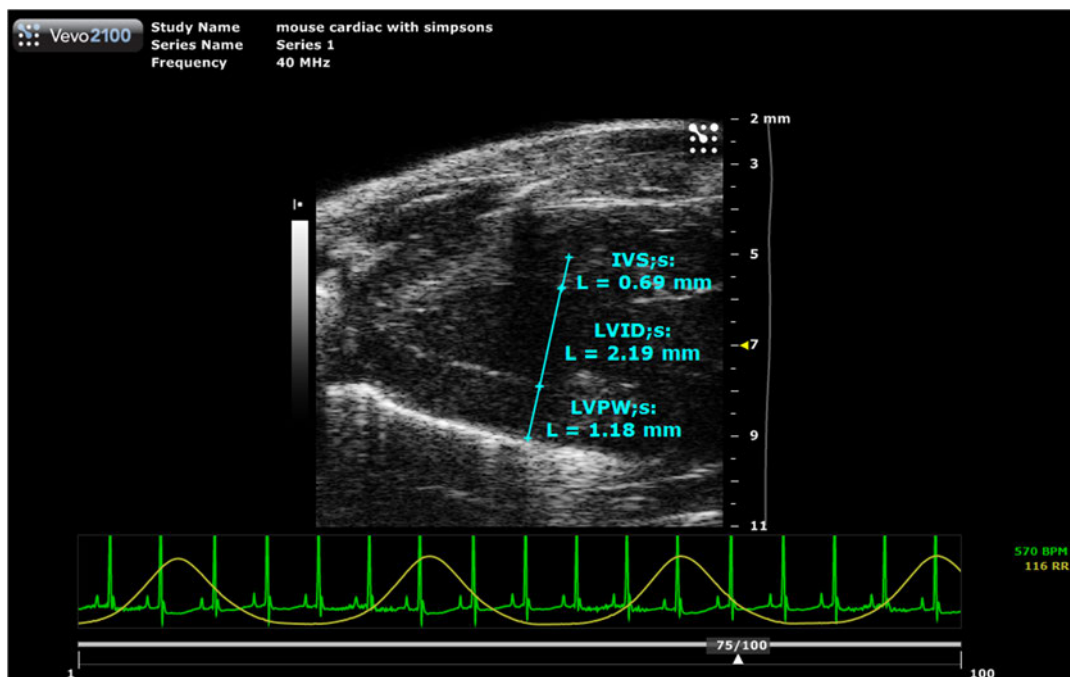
Parasternal Long Axis (PSLAX) and IVS, these measures provide the thickness of the interventricular septum.
